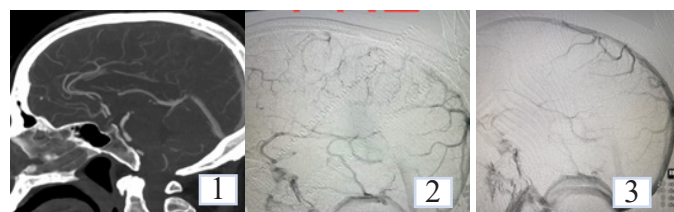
Preoperative CT Angiography shows thrombus at SSS and feeling defect
